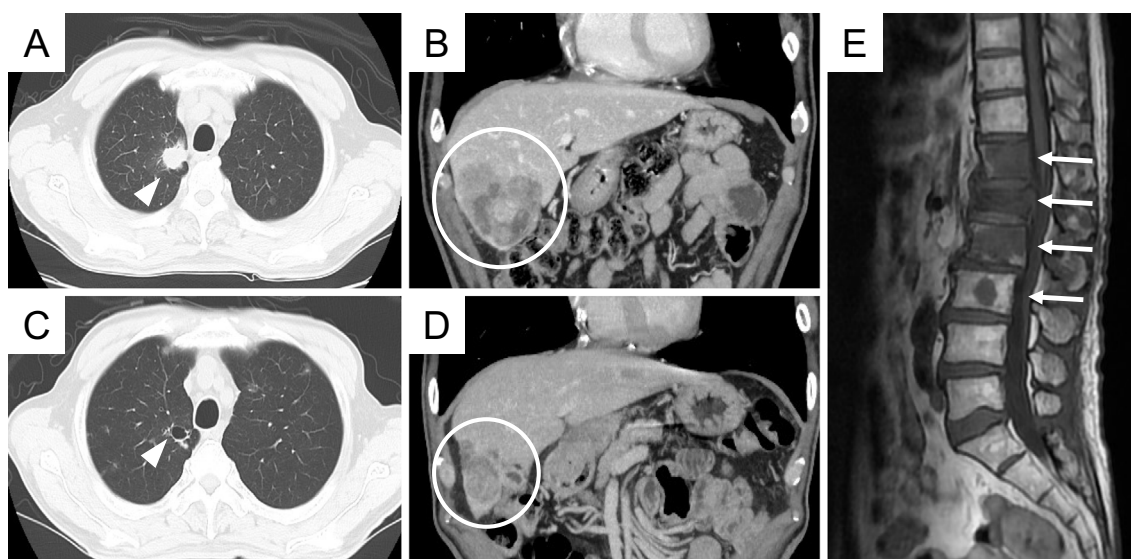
CT findings of lung cancer (arrowhead; A, C) and HCC (circle; B, D) clinical course showed an isolated pulmonary nodule in the right upper lobe (A) and multiple liver masses (B). After four cycles of ABCP chemotherapy, the lung and liver tumors (C, D) decreased in size. Sagittal T2-weighted magnetic resonance imaging revealed bone metastases at the Th10 and L1 to L5 spinal levels. Vertebral lesions of Th12 to L3 are indicated (arrow; E). ABCP: atezolizumab, bevacizumab, carboplatin, and paclitaxel, CT: computed tomography, HCC: hepatocellular carcinoma, MRI: magnetic resonance imaging
